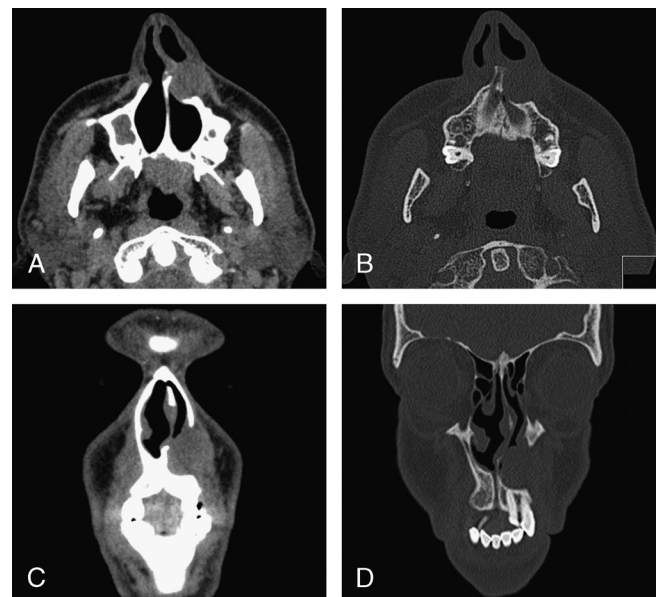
Axial (A, B) and coronal (C, D) CT scans revealing a well-demarcated, low-density cystic lesion lateral-anterior to the piriform aperture, with remodeling of the underlying anterior maxilla.
